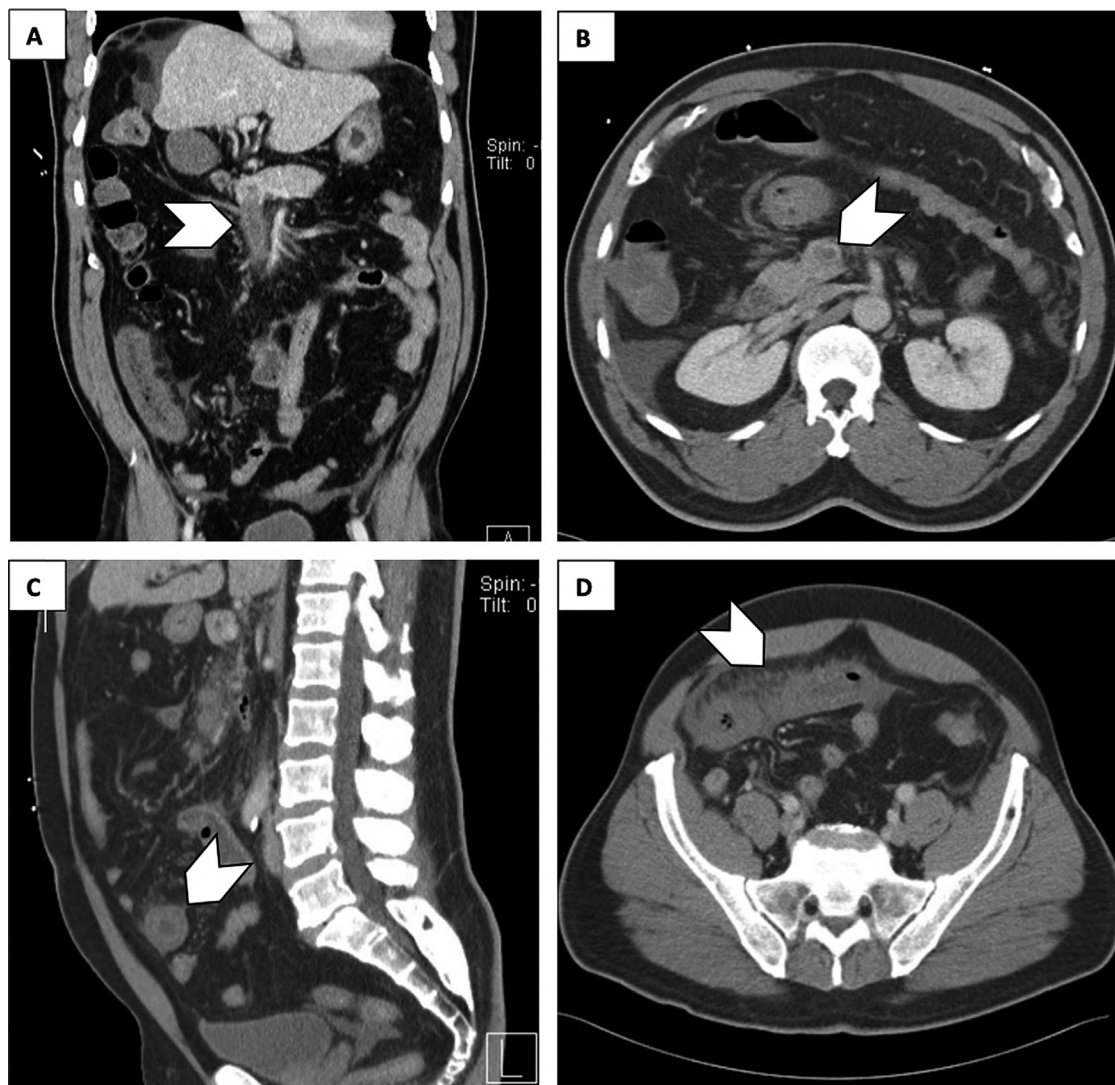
1A–1D: Contrast-enhanced abdominal computed tomography images from the diagnostic workup of the presented patient. 1A–1B: thrombosis of the SMV demonstrated on coronal and axial views as a filling defect indicated by white arrowheads. 1C: “Halo sign” of a small bowel loop demonstrated on sagittal view, representing stratification of the bowel wall by a central layer of edema, indicated by white arrowhead. 1D: marked bowel wall thickening and adjacent mesenteric fat stranding noted in the right lower quadrant, indicated by white arrowhead. Also noted by the interpreting radiologist was thrombosis of several distal SMV branches (not demonstrated here).
